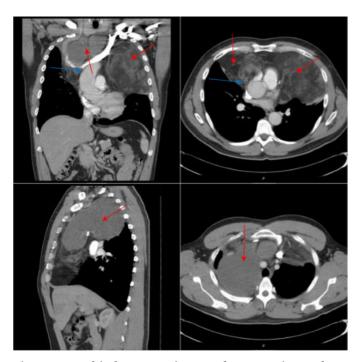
Multi-planar CT images demonstrating a large mediastinal tumor (red arrows) with SVC and innominate vein compression. There is complete obliteration of the SVC in the coronal and axial planes (blue arrows).
